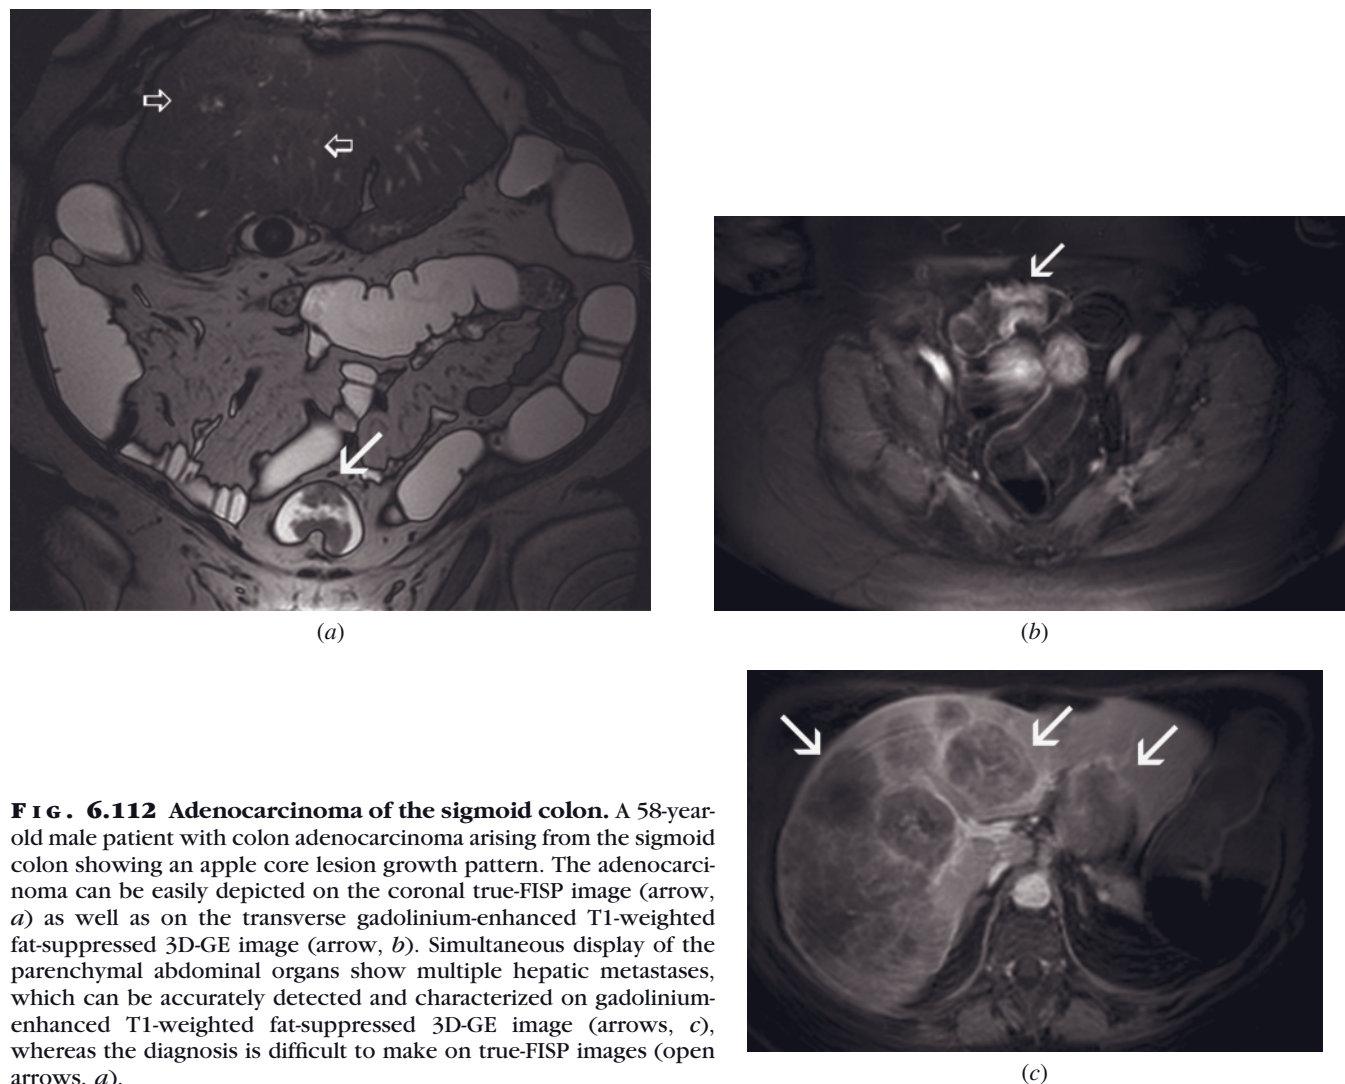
Adenocarcinoma of the sigmoid colon. A 58-year-old male patient with colon adenocarcinoma arising from the sigmoid colon showing an apple core lesion growth pattern. The adenocarcinoma can be easily depicted on the coronal true-FISP image (arrow, *a*) as well as on the transverse gadolinium-enhanced T1-weighted fat-suppressed 3D-GE image (arrow, *b*). Simultaneous display of the parenchymal abdominal organs show multiple hepatic metastases, which can be accurately detected and characterized on gadolinium-enhanced T1-weighted fat-suppressed 3D-GE image (arrows, *c*), whereas the diagnosis is difficult to make on true-FISP images (open arrows, *a*).
